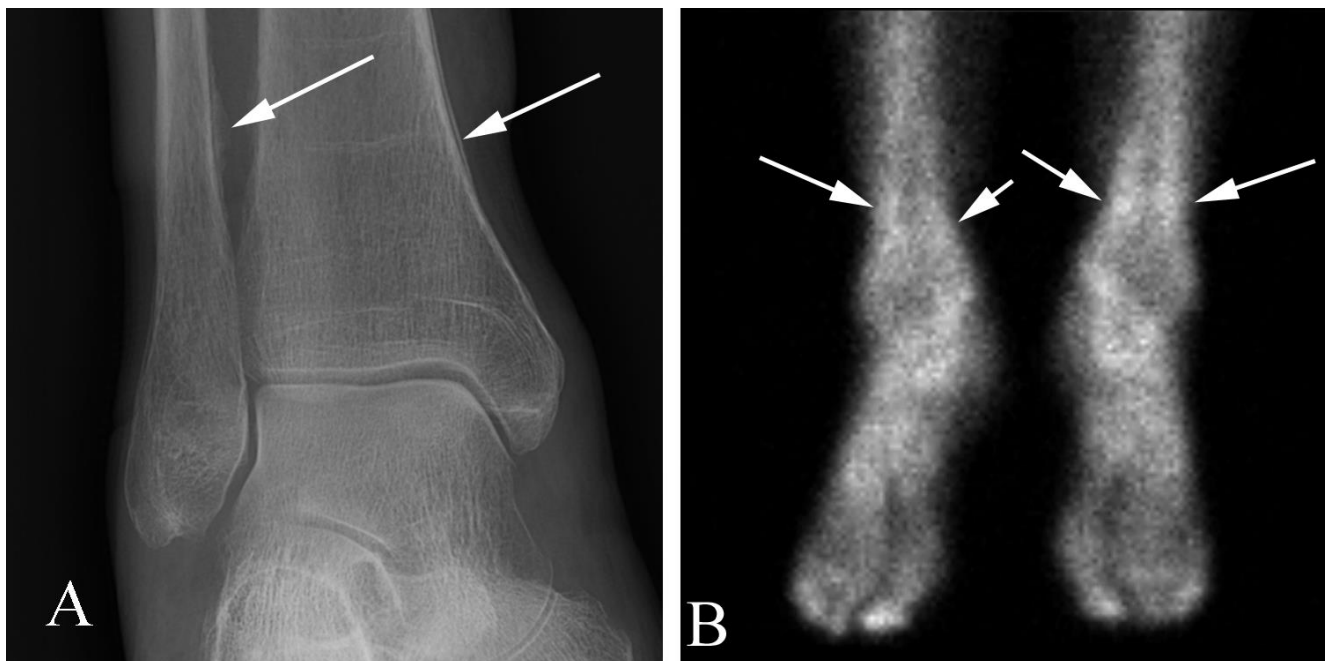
Hypertrophic pulmonary osteoarthropathy in a 74 year old woman with chronic ankle pain and lung cancer. A. Mortise view of the right ankle demonstrates diffuse periostitis along the distal fibula and tibia (arrows). The contralateral ankle (not shown) showed similar findings. B. Nuclear medicine bone scan shows diffuse increased radiotracer localization through both feet and ankles, including along the cortical margins of the distal tibia and fibula bilaterally (arrows). Chest CT (not shown) showed a large lung mass that proved to be cancer.
